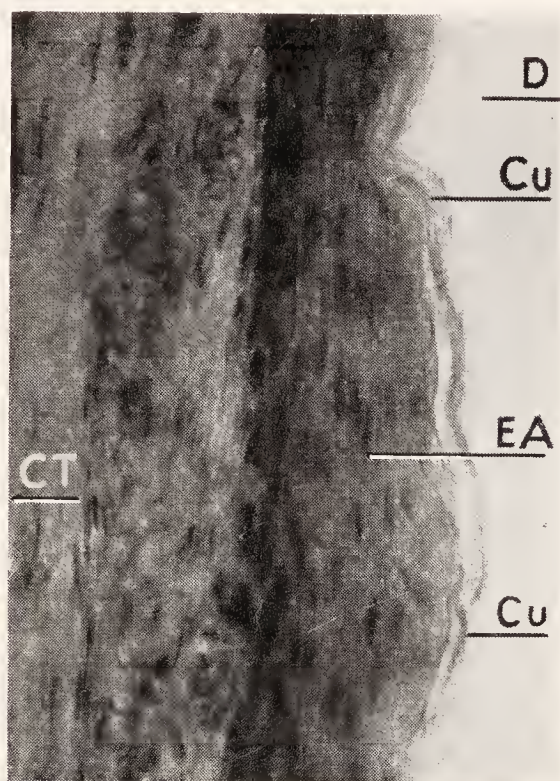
Higher magnification of EA" in Fig. 128. D, dentin; Cu, hornified secondary cuticle on the resorbed dentin surface; EA, stratified squamous epithelial cells of the epithelial attachment; CT, connective tissue.
